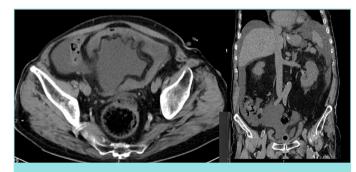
Computed tomography images of the bladder rupture and intra-abdominal fluid.
